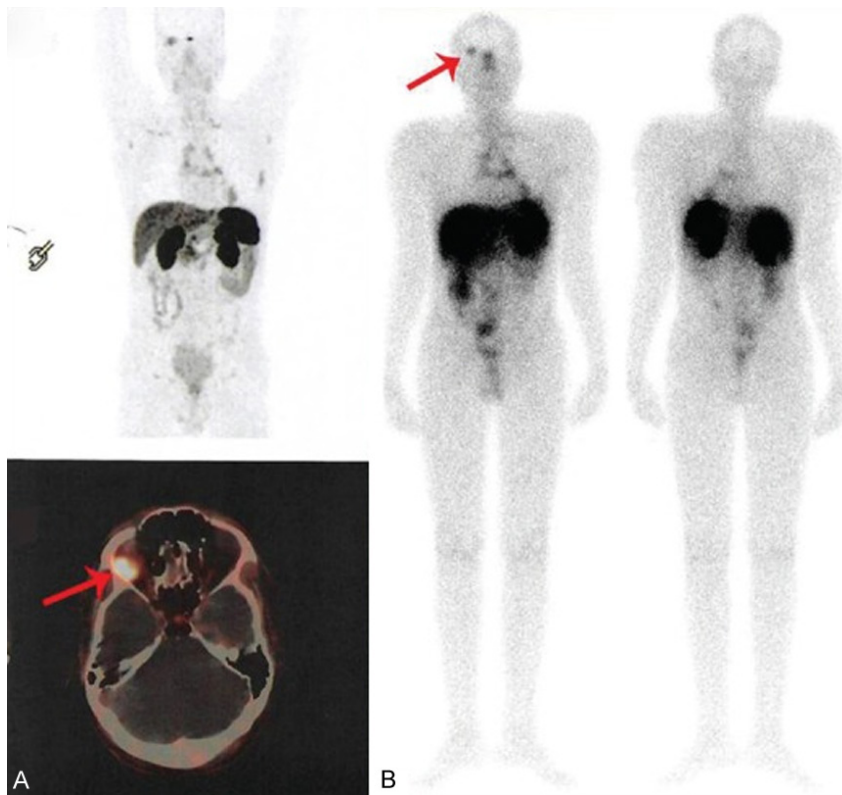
[⁶⁸Ga]Ga-DOTATATE PET/CT and treatment response in a patient with meningioma. A. [⁶⁸Ga]Ga-DOTATATE PET/CT demonstrates tracer uptake in the primary thymic neuroendocrine tumor and abnormal focal uptake at the right retrobulbar region adjacent to the optic nerve (red arrows), subsequently confirmed as a meningioma using MRI. B. Post-therapy [¹⁷⁷Lu]Lu-DOTATATE scan following four treatment cycles shows radiotracer accumulation within the meningioma (red arrow). At 26-month follow-up, the patient exhibited complete resolution of neurological symptoms with durable disease control, highlighting the potential of peptide receptor radionuclide therapy (PRRT) in meningioma management. Reproduced from Parghane RV et al. World J Nucl Med. 2019 Apr-Jun;18(2):160-170 with permission [84].
